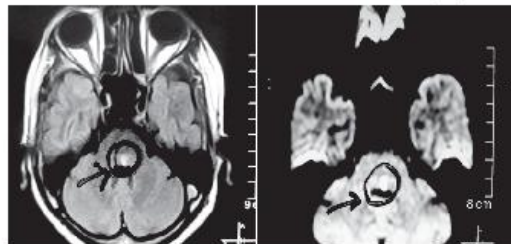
Hyperintensity on FLAIR and restricted diffusion area on Diffusion-weighted imaging sequence, in the left pontine tegmentum just anterior to the fourth ventricle.
